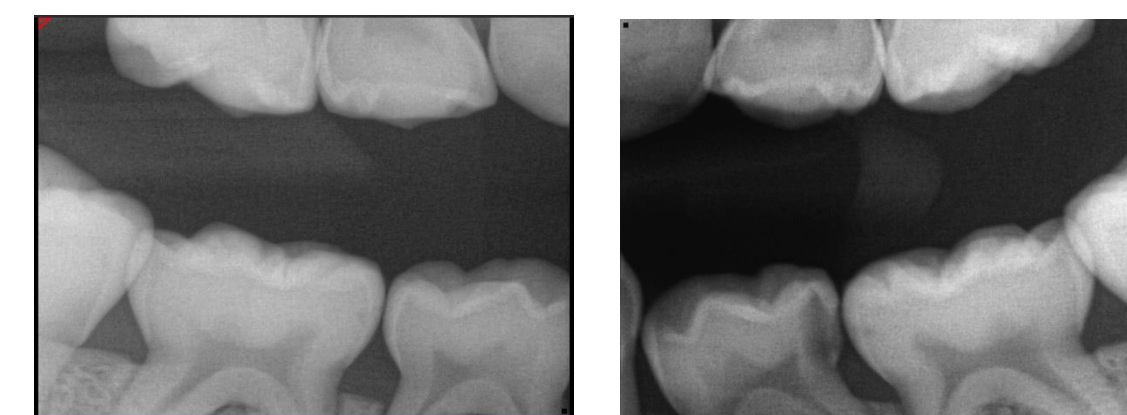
Bitewing radiographs
